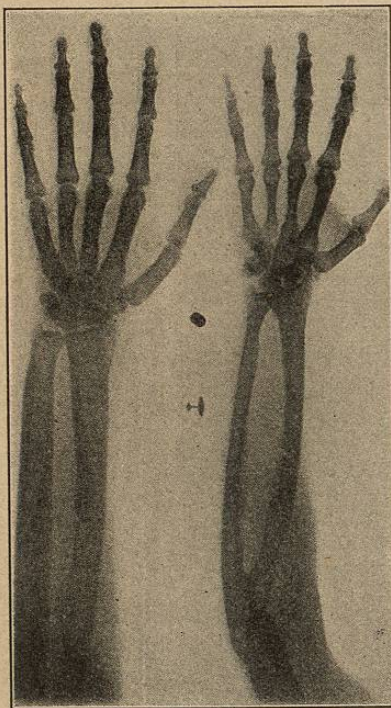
Radiographs of the Hand and Arm of a Case of Hypertrophic Pulmonary Osteoarthropathy (the left figure) compared with the hand and arm of a normal individual of the same height (the right figure). Note especially the thickening of the radius and ulna. (Thayer.)
